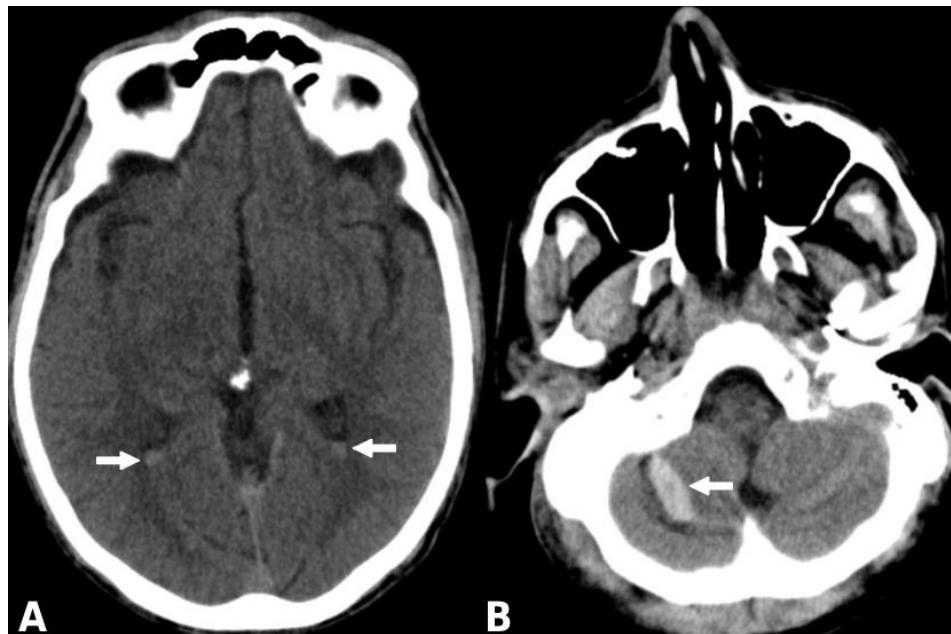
The initial CT of the patient showing A/ Intraventricular hemorrhage (arrows); B/ Contusion of the right cerebellar hemisphere (arrow).
